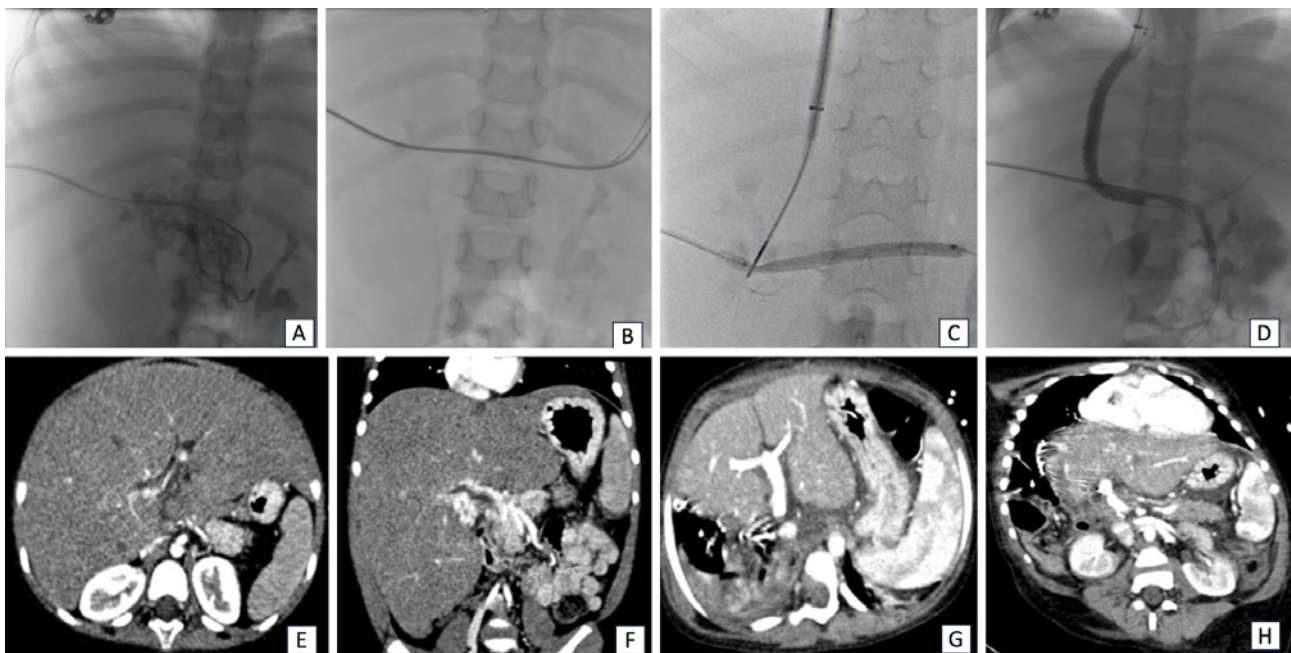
Portal vein recanalization with transjugular intrahepatic porto systemic shunt (PVR-TIPS) using transhepatic access. (A) Direct transhepatic portal venogram showing cavernoma and absence of the main portal vein. (B) The thrombosed portal vein is crossed using a KMP catheter and glidewire. (C) The contrast-inflated balloon is used as a fluoroscopic target and advancing the TIPS needle through the balloon. (D) Patent portal vein and TIPS at the conclusion of the procedure. (E, F) Pre-PVR-TIPS dynamic axial and coronal CT demonstrating chronic portal vein thrombosis and extensive cavernoma. After PVR-TIPS, the patient was transplanted and received an end-to-end anastomosis. (G, H) Dynamic axial and coronal CT during transplant follow-up demonstrates portal vein patency.
